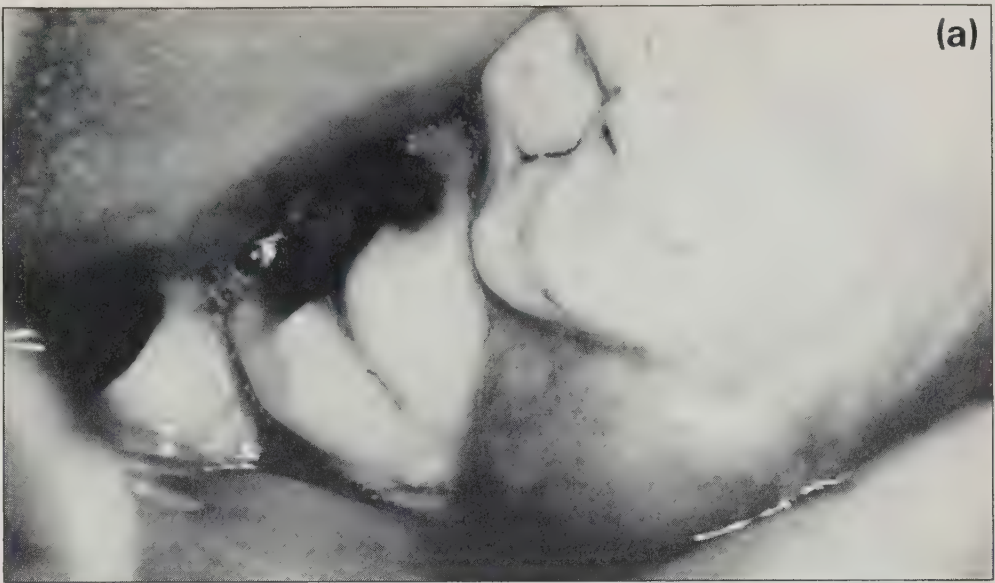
A severe acute periodontal abscess with systemic symptoms. 2(a) demonstrating buccal swelling encroaching upon the fascial planes; 2(b) pre-surgical radiograph of region after tooth 48 was removed, and occlusion stabilized with intracoronal splinting. Advanced periodontal pocketing and furcation involvement were prominent; however, the acute symptoms had resolved at this stage; 2(c) two-month postsurgical view, demonstrating complete resolution of the abscess condition and restoration of a healthy periodontium.
